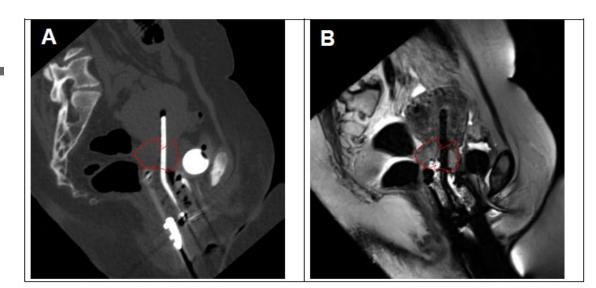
Sagittal view of a GYN patient with a titanium tandem and ring applicator set, including a rectal retractor on (A) CT (Philips Brilliance large bore CT) and (B) MRI (sagittal 2D T2W FSE sequence acquired on a 3.0T Siemens Skyra MRI scanner). The high risk CTV is depicted in the red contour.
